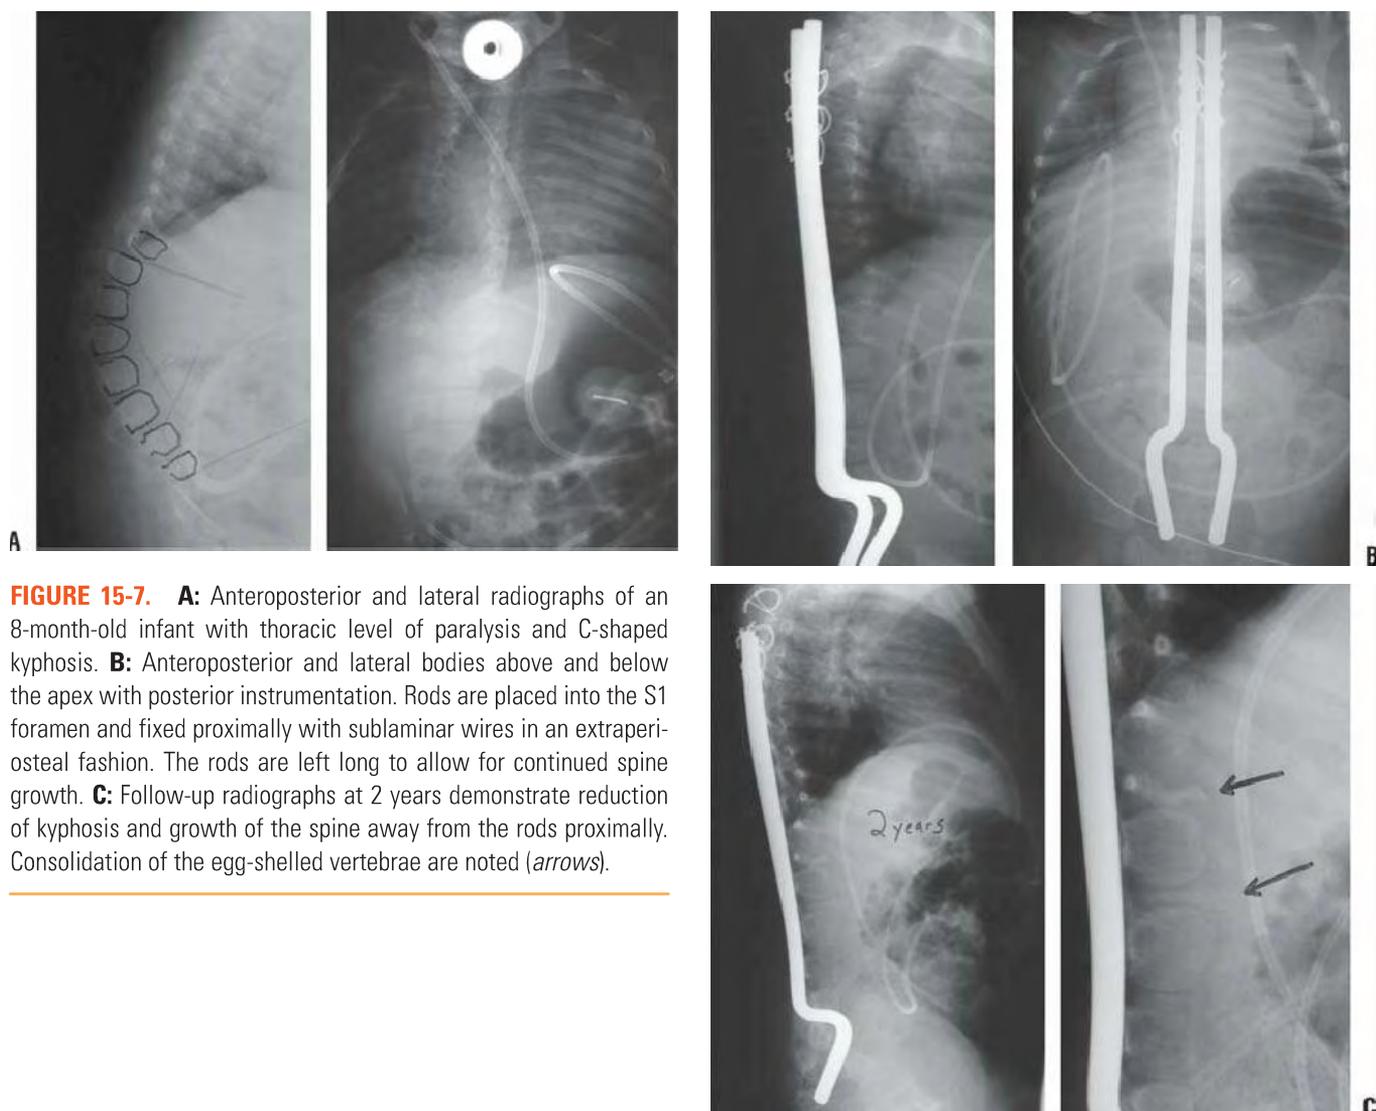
A: Anteroposterior and lateral radiographs of an 8-month-old infant with thoracic level of paralysis and C-shaped kyphosis. B: Anteroposterior and lateral bodies above and below the apex with posterior instrumentation. Rods are placed into the S1 foramen and fixed proximally with sublaminar wires in an extraperiosteal fashion. The rods are left long to allow for continued spine growth. C: Follow-up radiographs at 2 years demonstrate reduction of kyphosis and growth of the spine away from the rods proximally. Consolidation of the egg-shelled vertebrae are noted (arrows).
